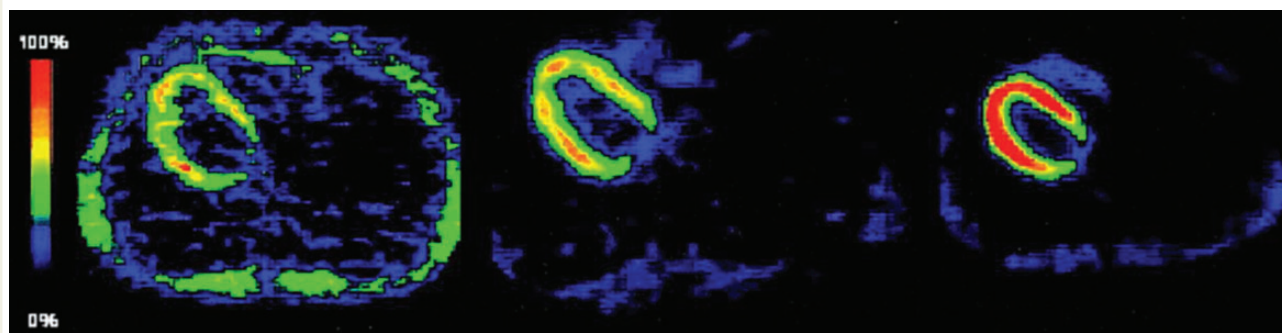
PET [^{18}F]FDG uptake in athletes. Examples of PET images showing similarly decreased [^{18}F]FDG uptake in endurance athletes and weight lifters compared with sedentary men (modified with permission, Takala et al.¹²⁶).
